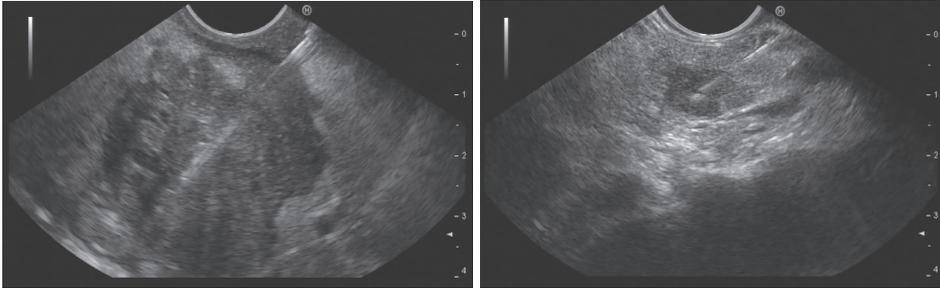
Endoscopic ultrasound images of hypodense lesions of the pancreatic head.
